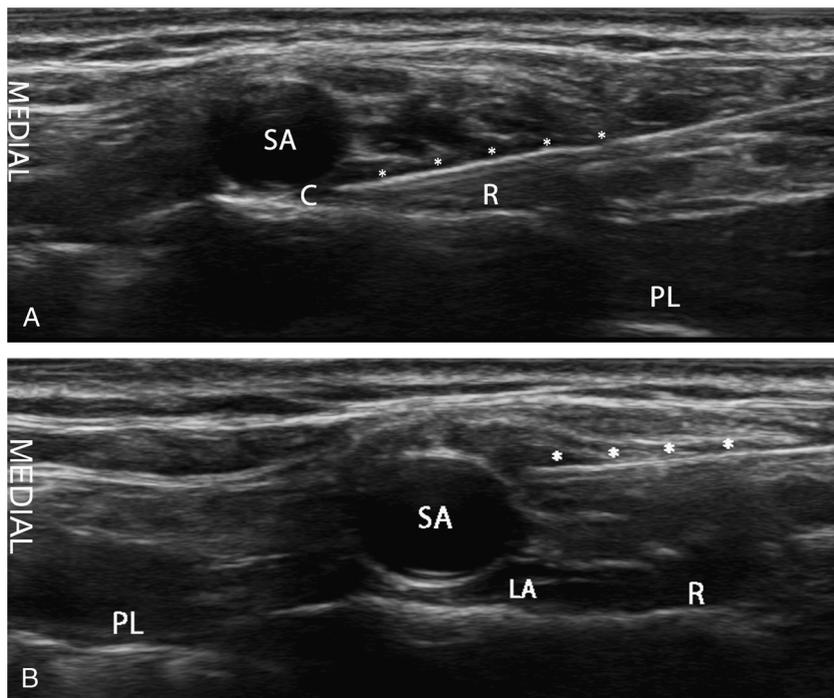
Transverse sonogram in the supraclavicular region. A, The needle (asterisk) was initially inserted into the corner pocket, and then (B) the needle was repositioned toward the nerve cluster. C indicates corner pocket; L, local anesthetic; PL, pleura; R, first rib; S, subclavian artery.
